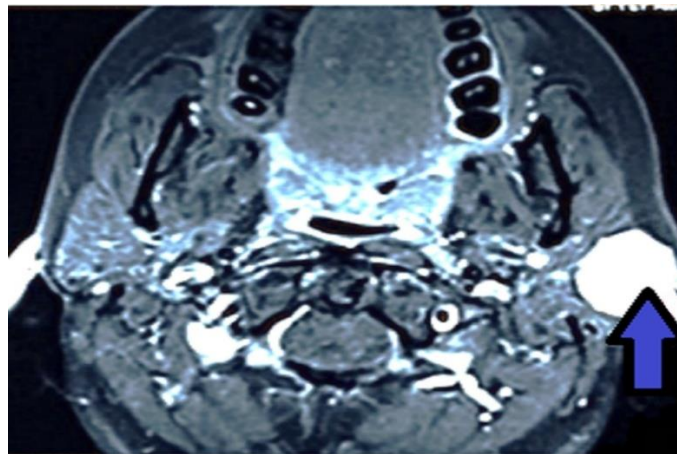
Axial T1 post-gadolinium MRI showing intense homogeneous enhancement of the lesion (blue arrow)
